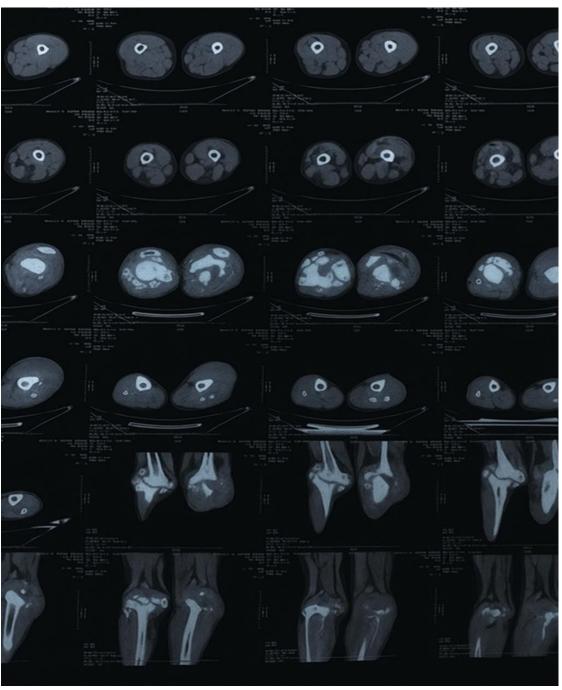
CT scan of the knees (case 1)
